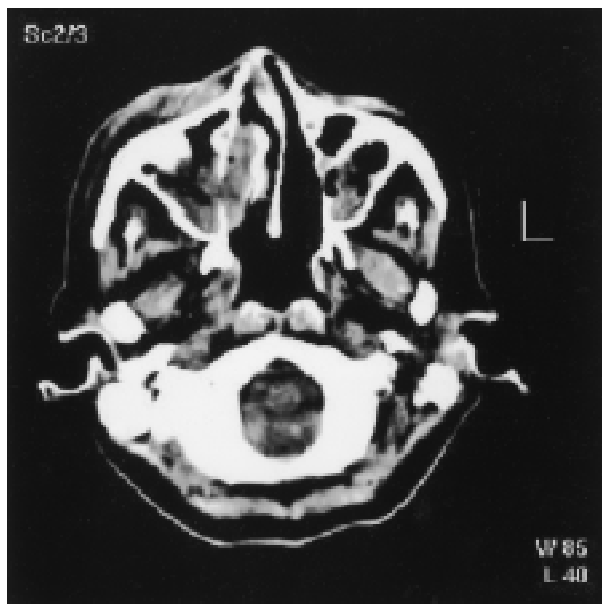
CT of paranasal sinuses (axial section) showing soft tissue mass lesion in right maxillary sinus with destruction of its medial wall
